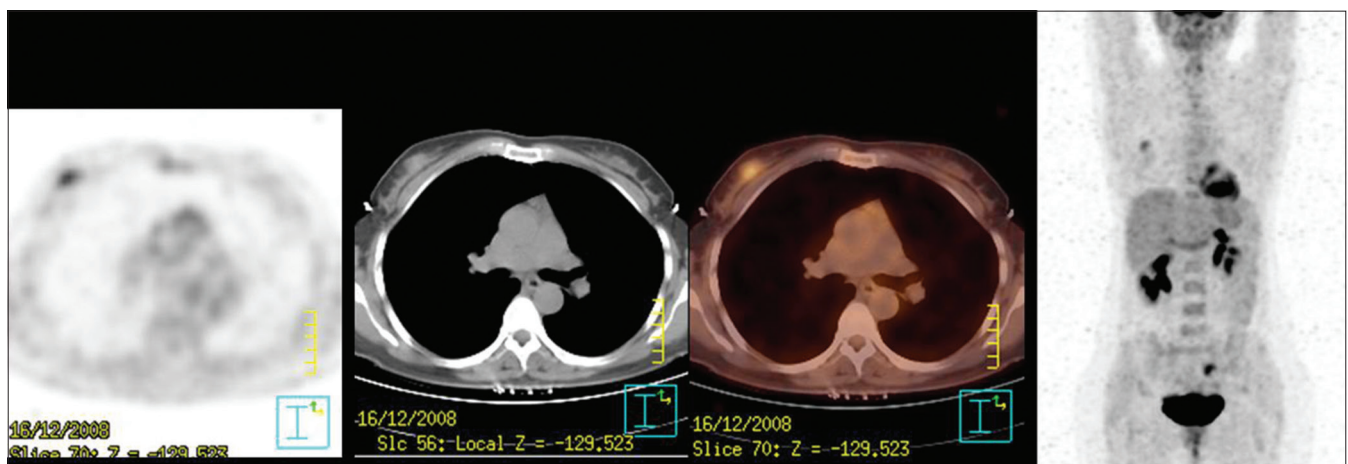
Right breast ER-positive, PR-positive, c-erbB 2-negative invasive ductal carcinoma, tumor size: 4 × 3 cm, SUVmax 1: 1.6, SUVmax 2: 1.6 (no change) (Reprinted with permission from Basu *et al.*^[8])
